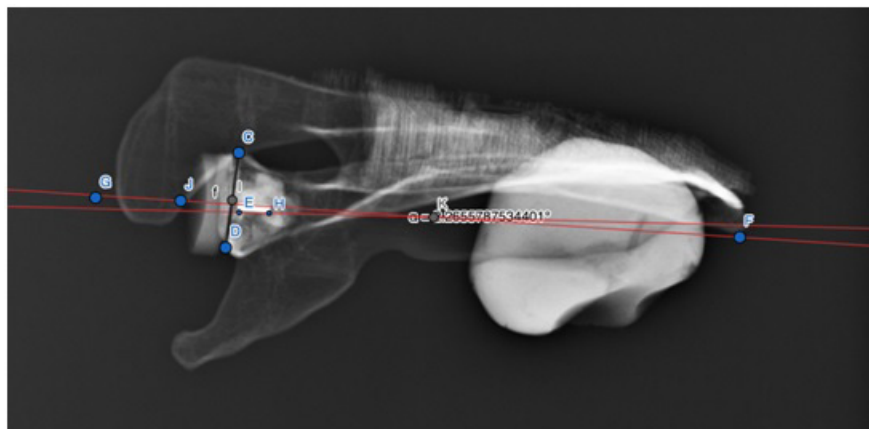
X-ray in axillary view of the model showing the lines and angle measures of the positioning of glenoidal component
